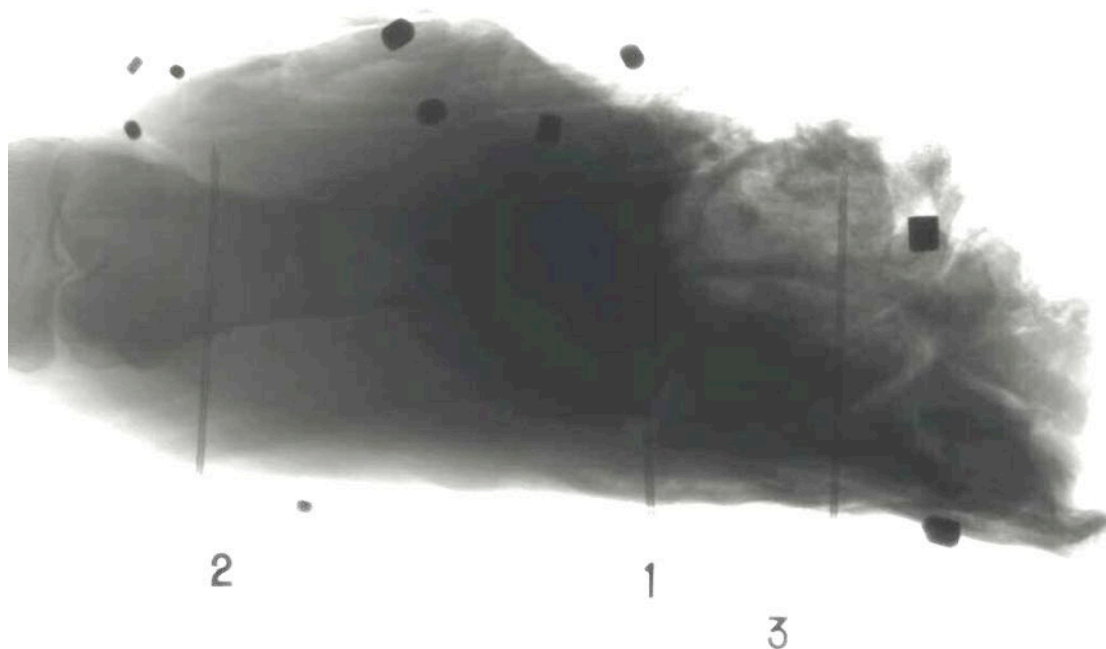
A plain radiograph of metal markers inserted into wound tracks; note FSPs lodged under contralateral skin surface.
